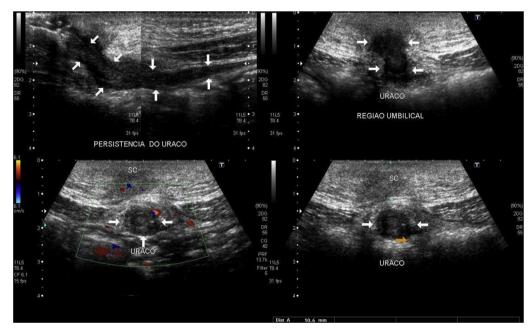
Ultrasonography of the lower abdomen showing a midline hypoechoic tubular structure posterior to the rectus abdominis muscle and ventral to the apex of the bladder, extending from the periumbilical region to the dome of the bladder, identified as the urachal remnant.
